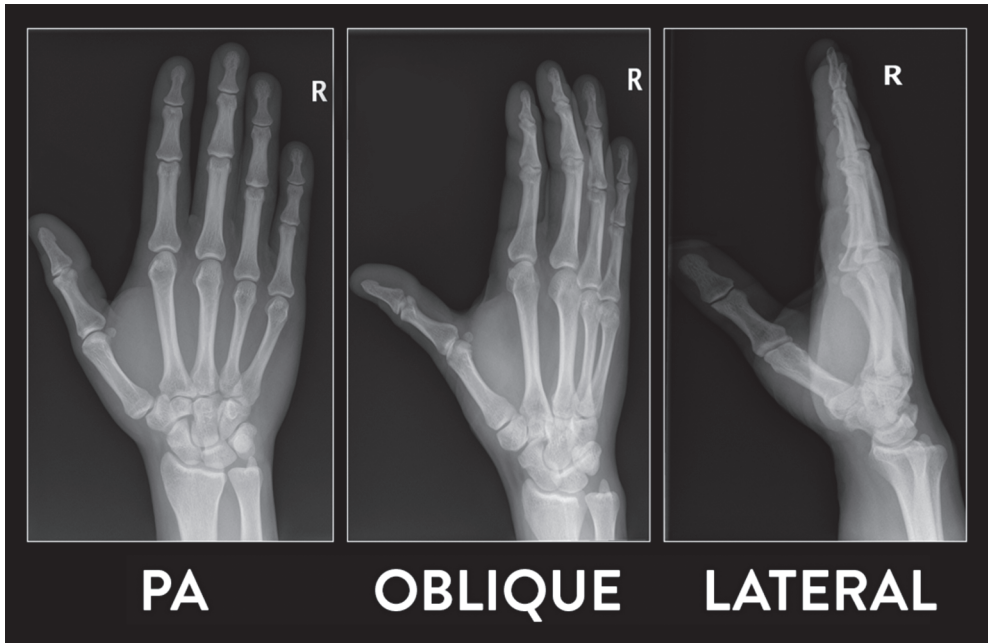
Routine radiographic hand series showing the posteroanterior (PA), oblique, and the lateral view. Case courtesy of Dr. Craig Hacking, Radiopaedia.org.
